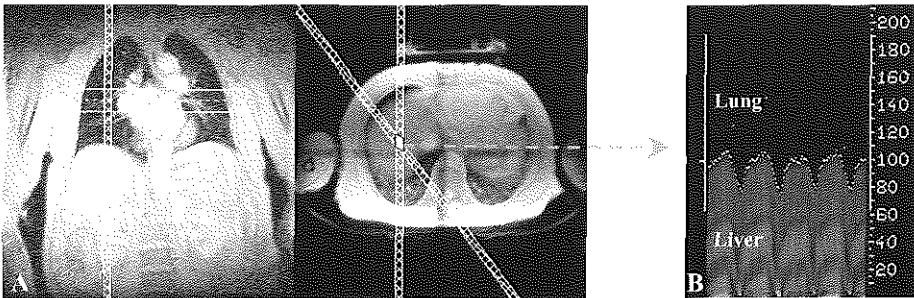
Retrospective respiratory gated magnetic resonance imaging of the coronary arteries. (A) Respiratory motion is determined by two excitation bands that intersected at the dome of the right hemidiaphragm. (B) Respiration pattern during 30 seconds. The diaphragm position is determined for each acquisition window. Retrospectively only data from end expiration are selected for image reconstruction.
